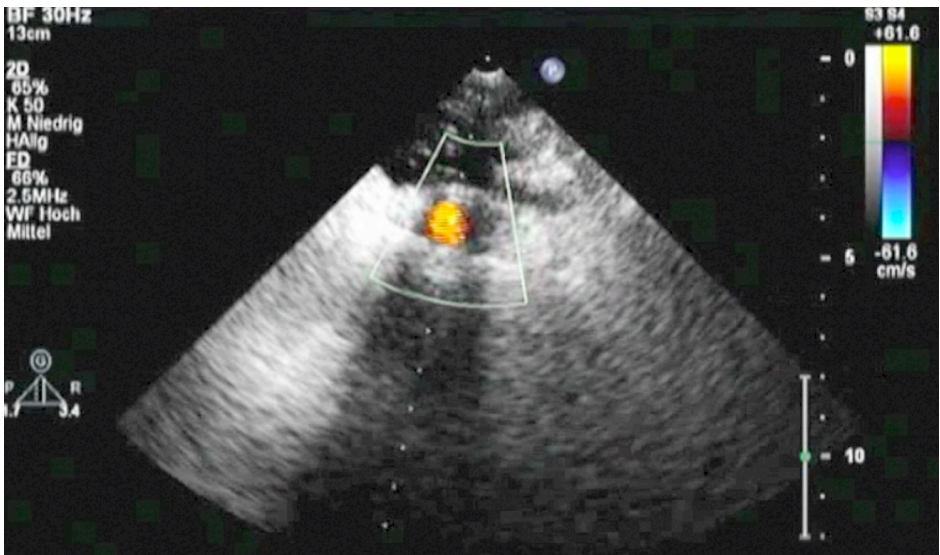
Outflow cannula visualization by right parasternal view
